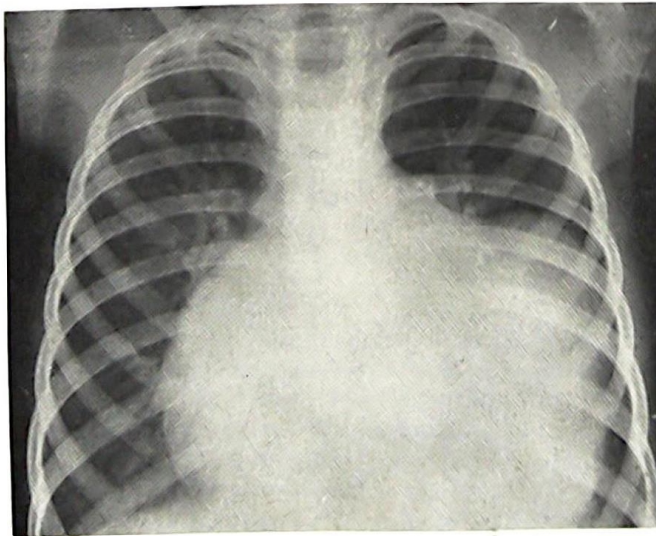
Chest radiograph of a 6-year-old girl with left ventricular submitral aneurysm. Note the characteristic aneurysmal shadow in the left heart border and also the cardiac enlargement.
